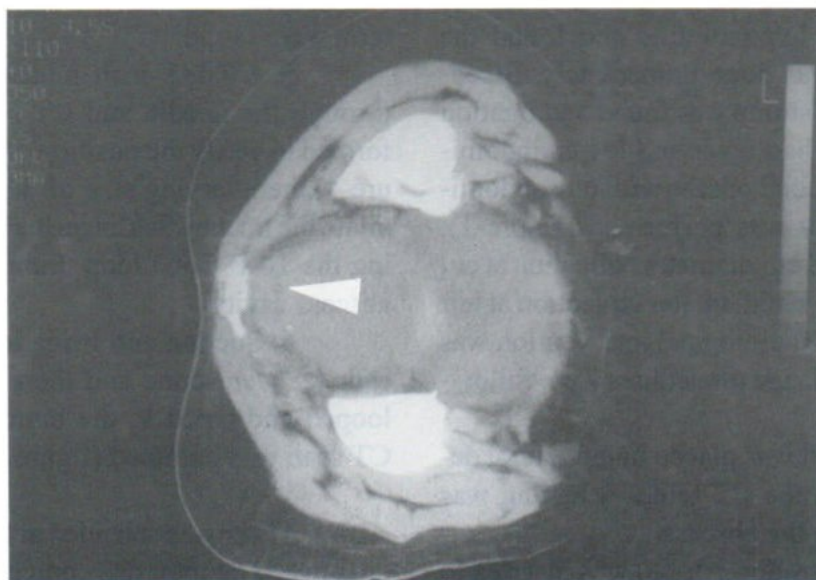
Left lateral decubitus CT scan of the lower pelvis demonstrates plastic introducer in the rectum at the level of the abscess
